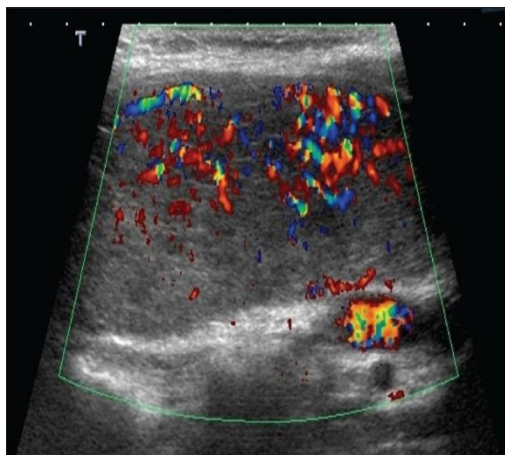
Doppler ultrasonography of thyroid revealed enlarged both thyroid lobes with hypervascularization, Figure 2: Thyroid scintigraphy showed intense radiotracer uptake in both thyroid lobes with diffuse thyromegaly.
